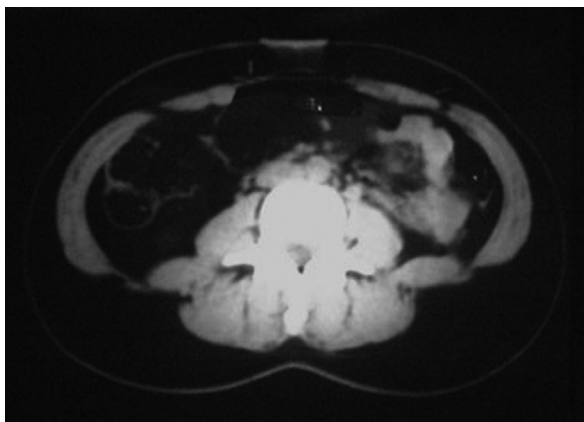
Pre-operative CT scan of the abdominal compartment, lumbar section. In the anterior side DIASTASIS RECTI is visible.
